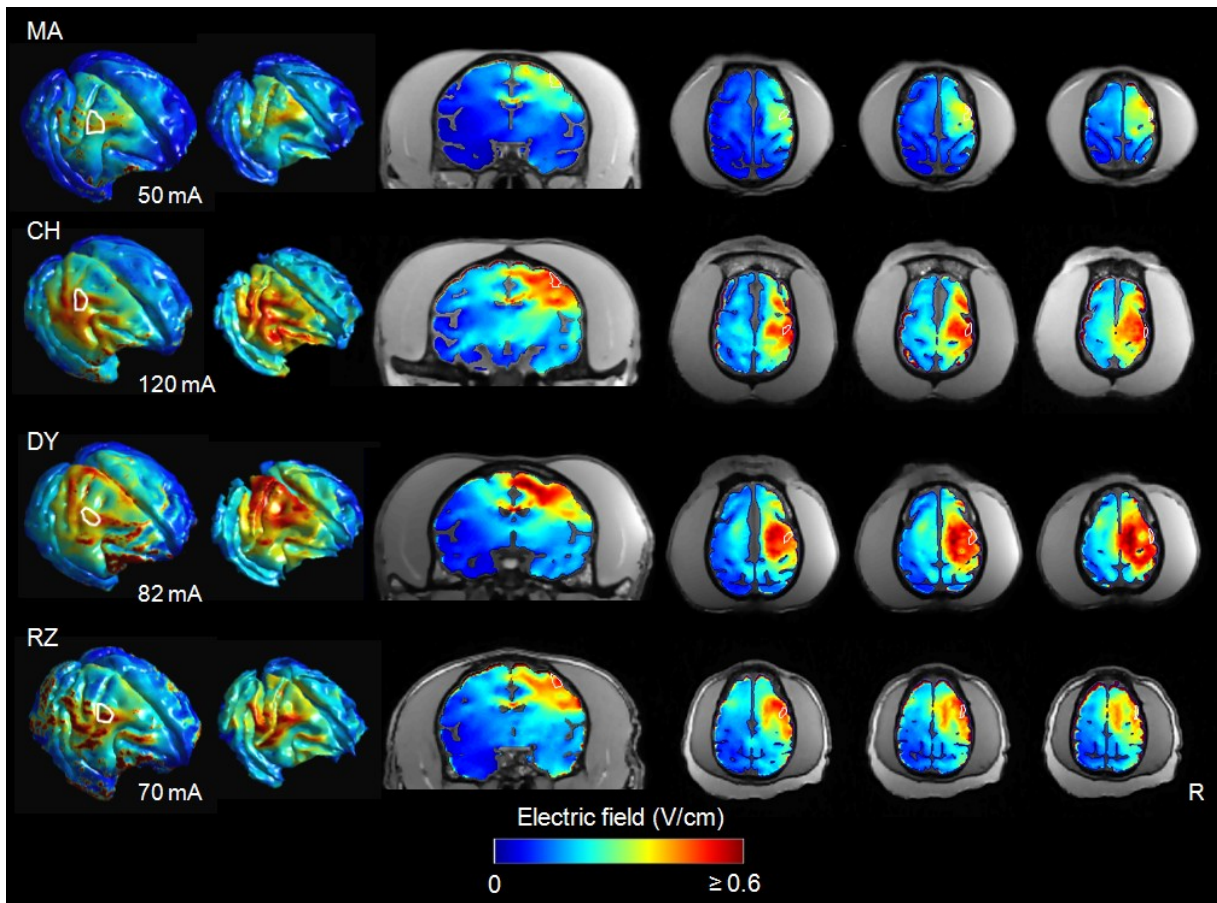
Electric field distribution at current strength corresponding to the individual MT for the four NHP subjects (top to bottom rows, respectively). Shown are electric field maps on the cortical surface (CSF–gray matter interface; first column), white matter surface (gray matter–white matter interface; second column), representative coronal slice (third column), and transaxial slices (fourth to sixth columns; 1.5 mm inter-slice distance). The structural MRI images of the extracerebral brain tissues are shown in gray around the slices as a reference to the anatomical results in Figure 5.6. Region-of-interest outlines in white show FDI motor area. Individual average MT is shown on the left below each row. R: right
